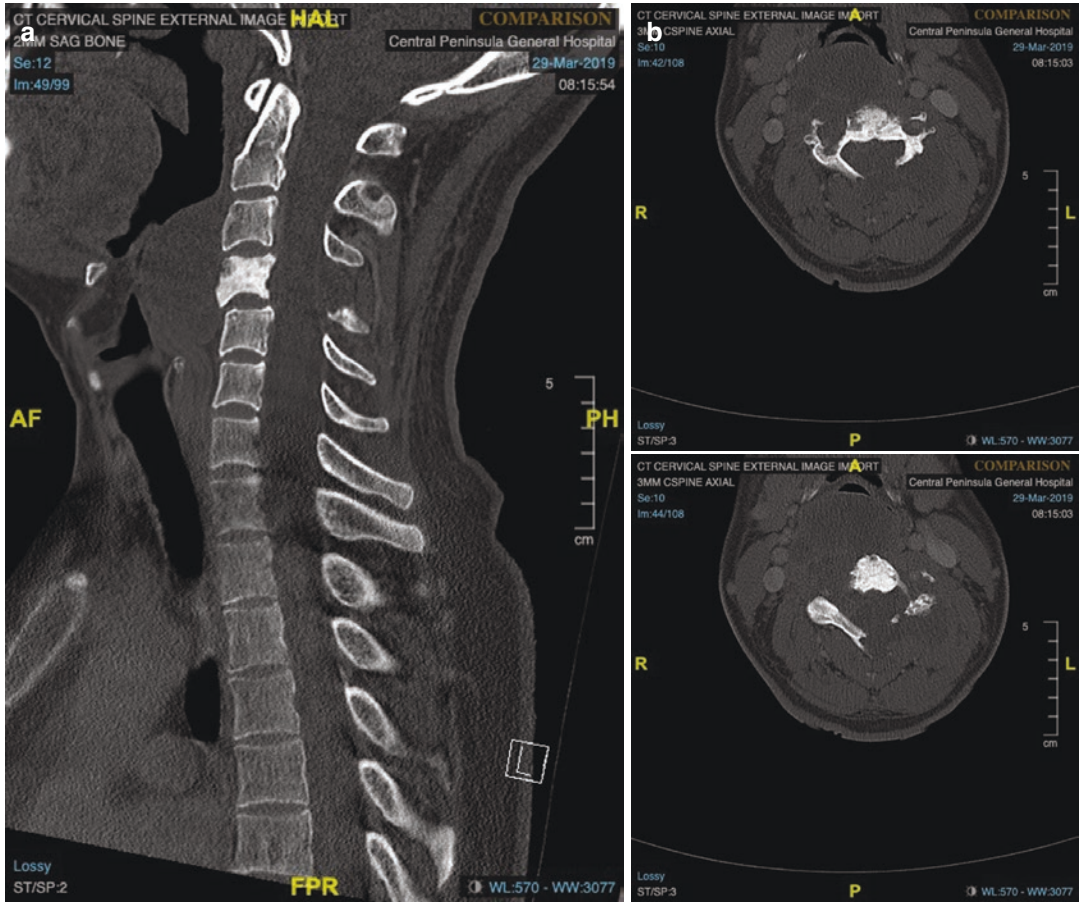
The case is a 33-year-old male with neck pain and dysphagia that has worsened over the past 10 years. He was found to have a large cervical mass and biopsy demonstrated chordoma. (a) Sagittal CT image demonstrating the bony changes at C4 with both sclerotic and lytic changes in the vertebral body and posterior elements. There is a large extensive soft tissue mass extending both anteriorly and posteriorly into the spinal canal. (b) Axial CT images demonstrating the bony changes with the large soft tissue mass. (c) Sagittal MRI images depicting the large soft tissue mass emanating from C4 but extending to C3 and C5 with severe spinal cord compression with spinal cord edema and cord signal change. (d) Axial MRI images depicting the tumor encasing the vertebral arteries bilaterally with severe circumferential spinal cord compression. (e) AP and lateral fluoroscopic images after bilateral vertebral artery angiogram and coiling procedure.
